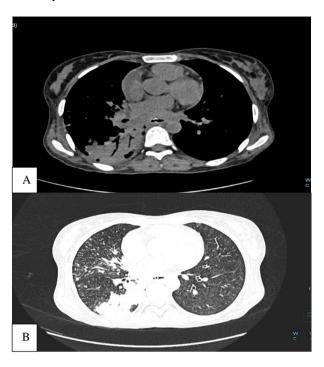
(A and B): HRCT thorax showing large patches of consolidation showing air bronchogram sign in the dependent part of right lung and tractional bronchiectatic changes with surrounding ground glass haziness.
